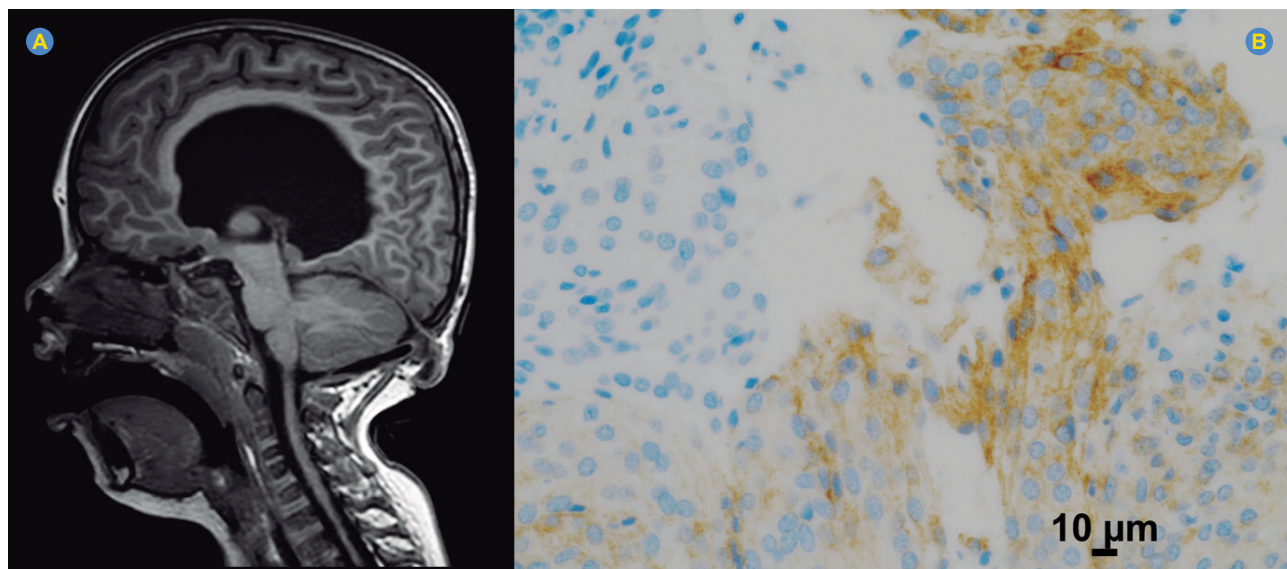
Neuroimaging (MRI, sagittal plane, T1-weighted): defect of the occipital bone with herniation of mainly meningeal tissue (meningocele) with associated voluminous hydrocephalus (A). Microphotograph showing expression for PD-L1 in pathological cells (40x) (B).
